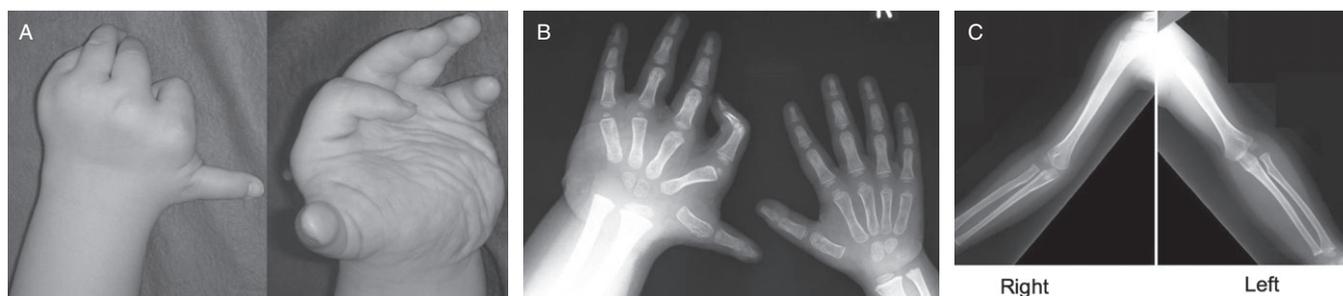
Case 1: 3-year-old boy. (A) The left hand was affected. The hand was hypertrophic and it looked like windblown hand but there was no thumb in palm deformity. The palm was bulky. (B) Under X-ray, the left hand was hypertrophic, the intermetacarpal spaces were wide and the thumb was extended and abducted. (C) The left arm was hypertrophic compared to an unaffected right side.
